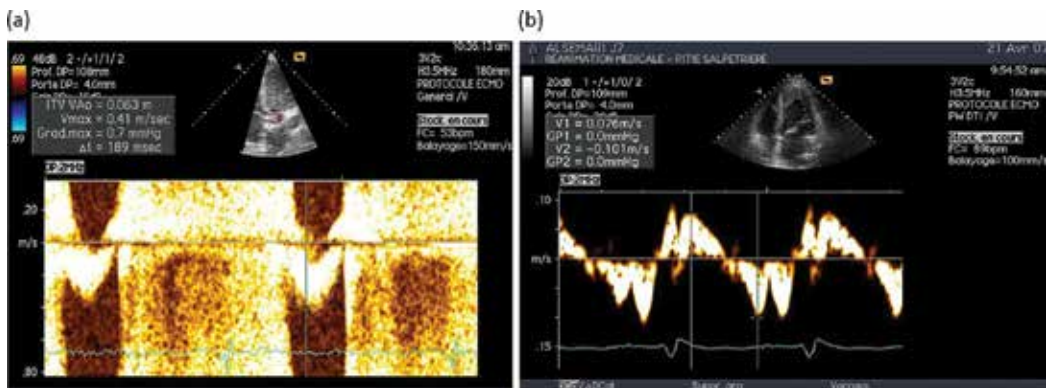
Echocardiographic variables measured by the Doppler method. A. Aortic velocity-time integration obtained by pulsed Doppler measured at the LV outflow tract. B. Lateral systolic peak obtained by spectral Doppler tissue imaging at the lateral mitral annulus.
